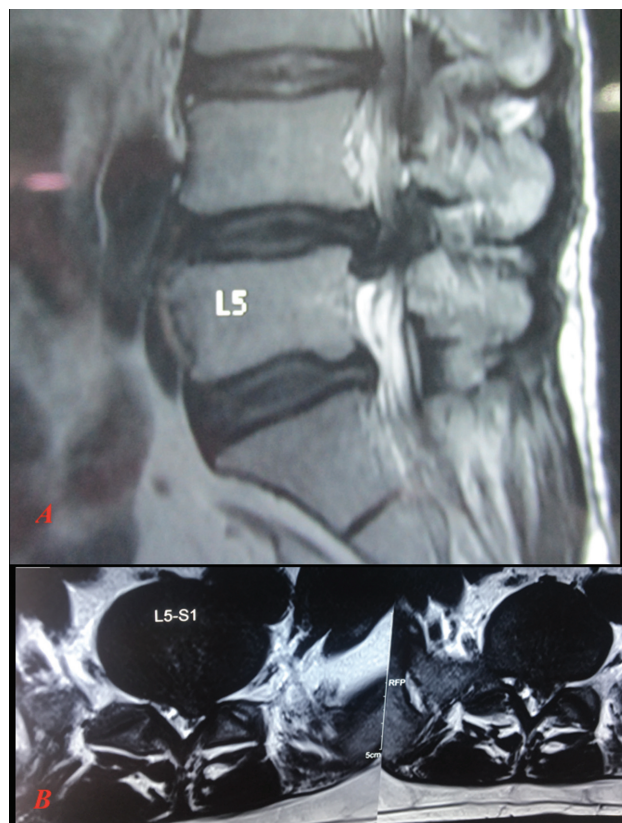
(A) Magnetic resonance imaging (MRI) of lumbar spine sagittal section showing L4 to L5 disc prolapse. (B) MRI of lumbar spine axial sections showing L5 to S1 left-sided disc prolapse with inferior migration of the disc fragment.
